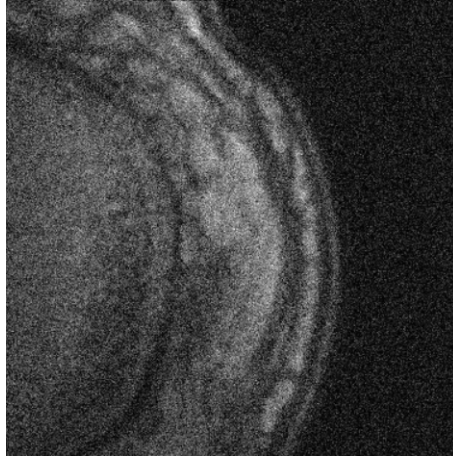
Noisy MRI skin image
